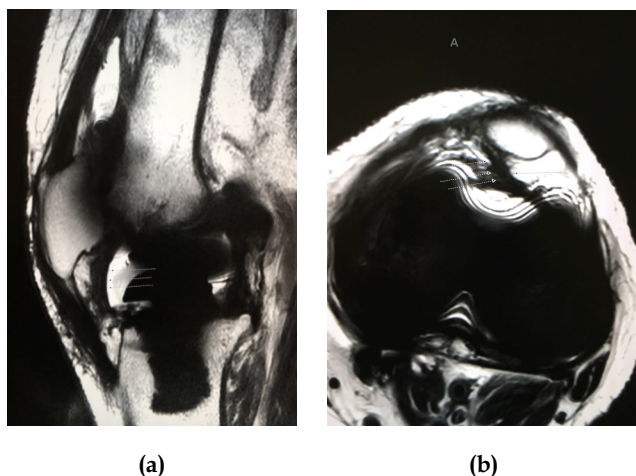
Sagittal (a) and axial (b) MRI images showing intraarticular fibrous bands (arrows).
